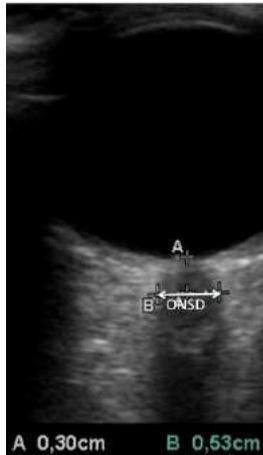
Ocular Sonography with Optic Nerve Sheath Diameter Measurement
